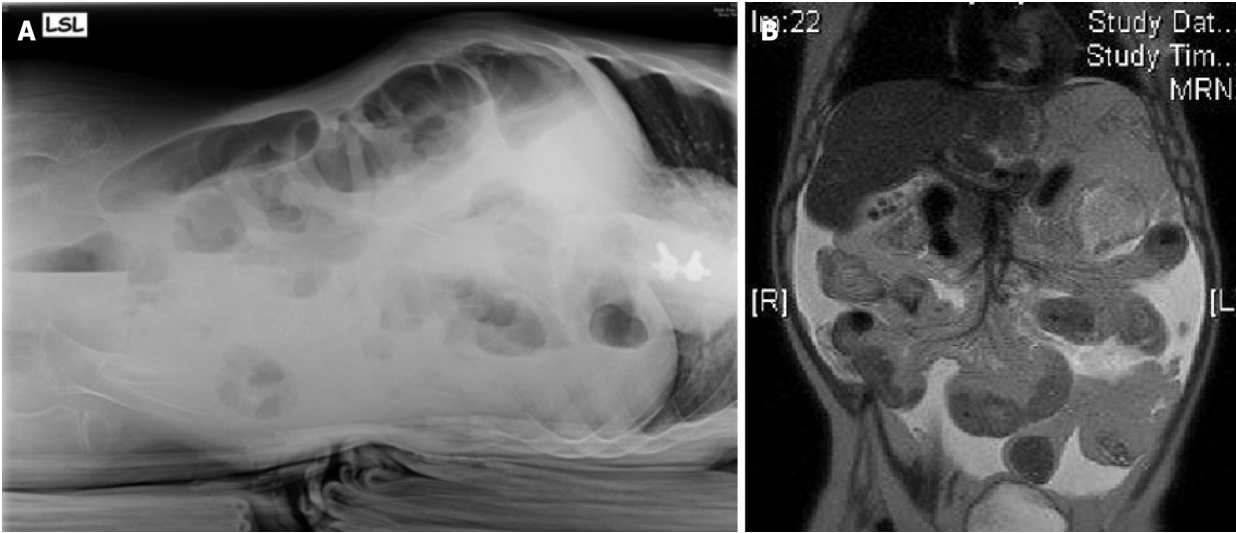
Diagnostic imaging. A: X-ray with lateral abdominal view showing some air fluid levels; B: Magnetic resonance imaging in coronal plane with distended duodenum and small bowel loops with multiple intraluminal air fluid levels and thickened walls.
